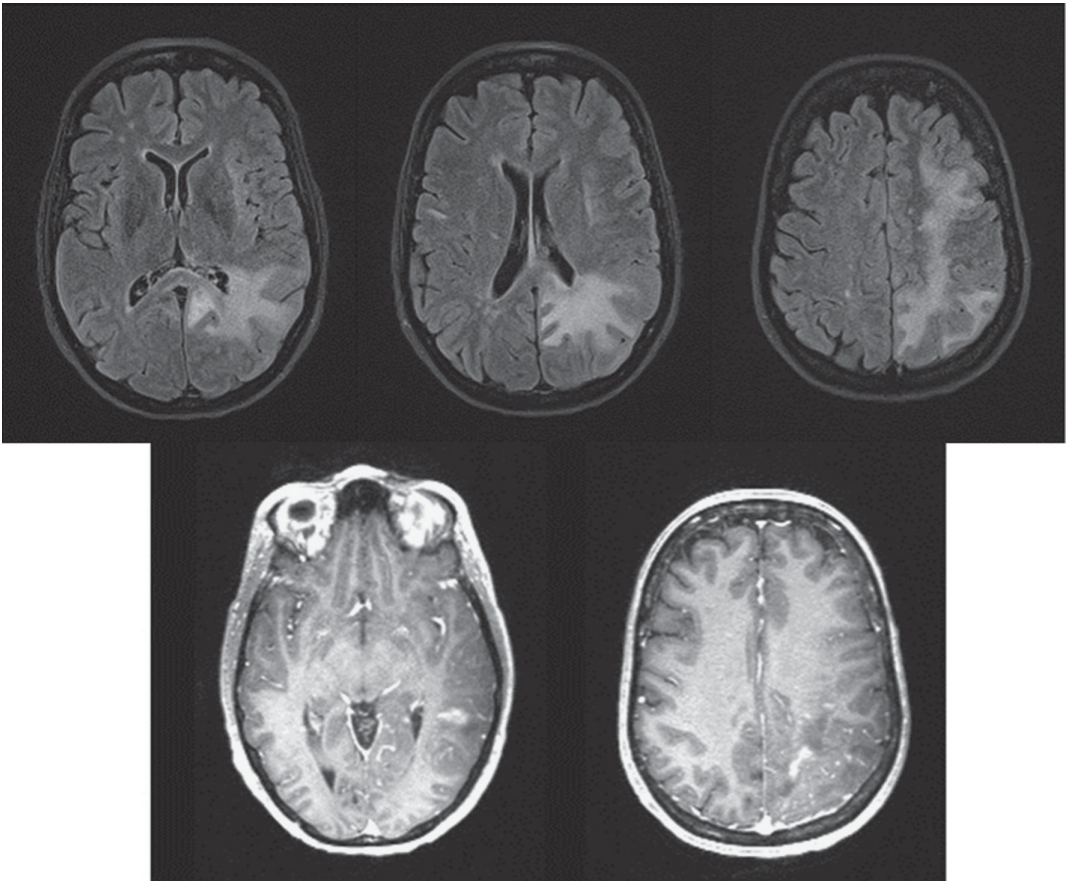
MRI 5 weeks after presentation, 4 weeks after plasmapheresis (top row-FLAIR sequence, bottom row-T1 post-gadolinium sequence). The extent of FLAIR abnormality has increased since Figure 1 and there is now patchy contrast enhancement.
